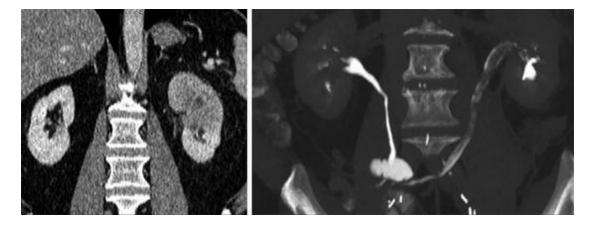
CT urography demonstrating an infiltrative left upper pole urothelial cell carcinoma with multiple lesions in the left ureter after cystectomy
